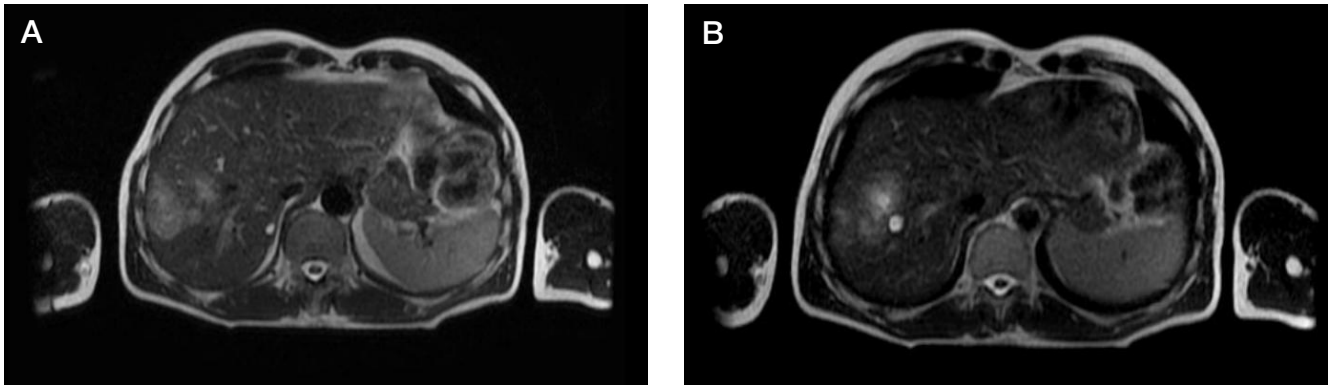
A, B. MRI scan, abdominal cavity, 15.07.2020
